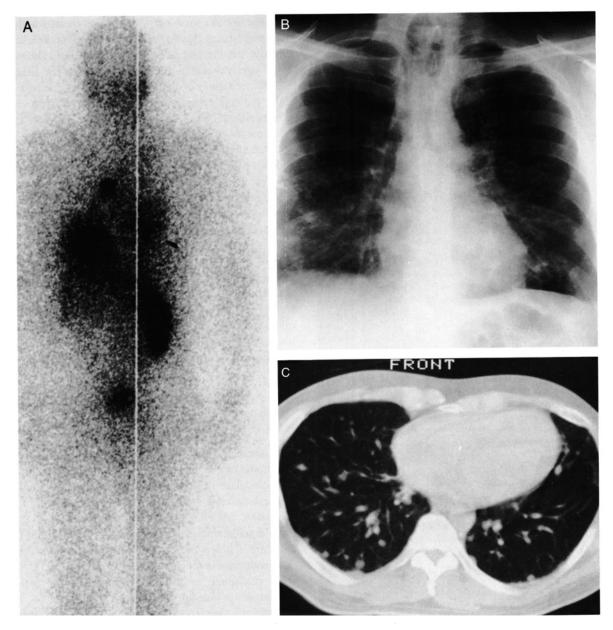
(A) ¹³¹I uptake, posterior, whole-body image, obtained 48 hr after ablation therapy with 250 mCi of ¹³¹I-Na, shows focal areas of increased uptake in the right neck, left hilar region of the chest, and right lung base. (B) A chest X-ray reveals multiple pulmonary nodules. (C) The CT scan of the chest also reveals multiple small pulmonary nodules.
